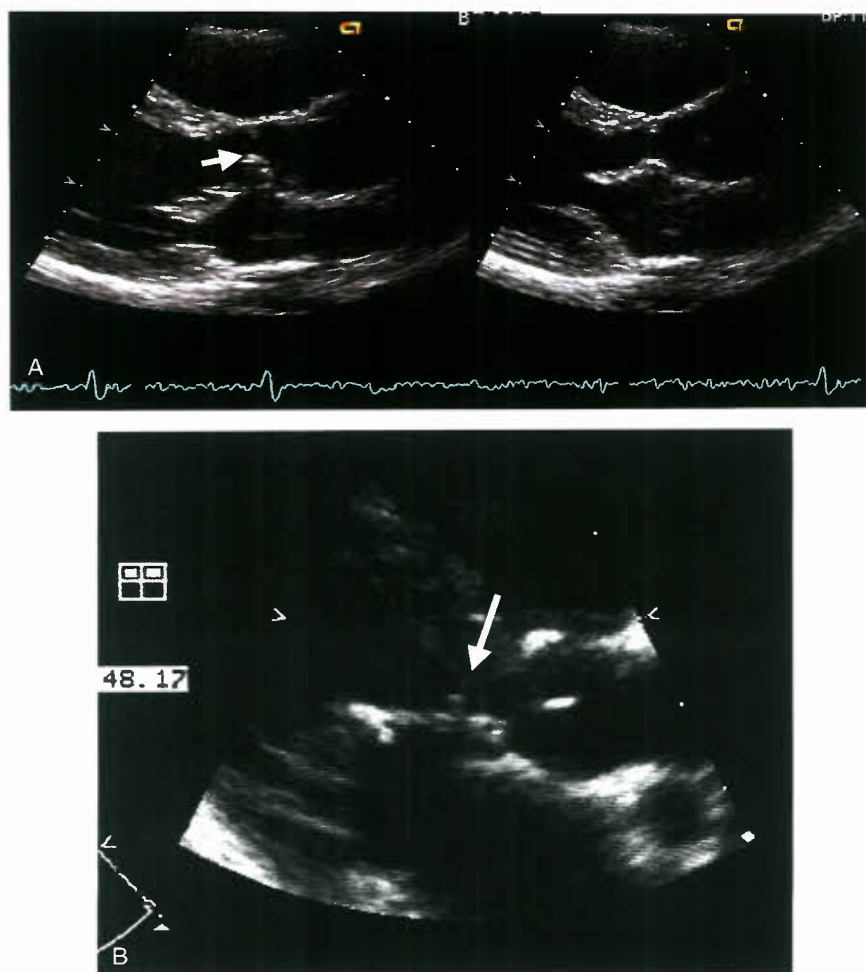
A: LVOT obstruction: systolic (left) and diastolic (right) echocardiograms demonstrating LVOT obstruction in a 17-year-old who had repair of a partial AVSD at age 15 months. LVOT obstruction (arrow) is usually progressive and may be undetected at time of initial repair. B: LVOT obstruction: parasternal long-axis projection demonstrating left AV valve attachments (arrow) to the septum in a patient after repair of partial AVSD. 10% to 15% of patients with AVSD require reoperation to relieve LVOT obstruction. Progressive LVOT obstruction is more common in partial than in complete AVSD. Mechanisms of LVOT obstruction include attachments of superior bridging leaflet to ventricular septum, extension of the anterolateral papillary muscle into the LVOT, discrete fibrous subaortic stenosis, tissue from an aneurysm of the membranous septum bowing into the LVOT.
